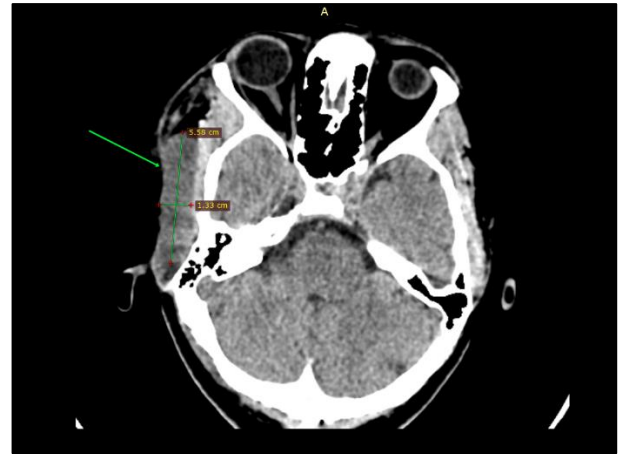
Axial section of CT showing a well-defined hypodense lesion (the arrow) in subcutaneous plane in right zygomatic region superficial to temporalis muscle.
